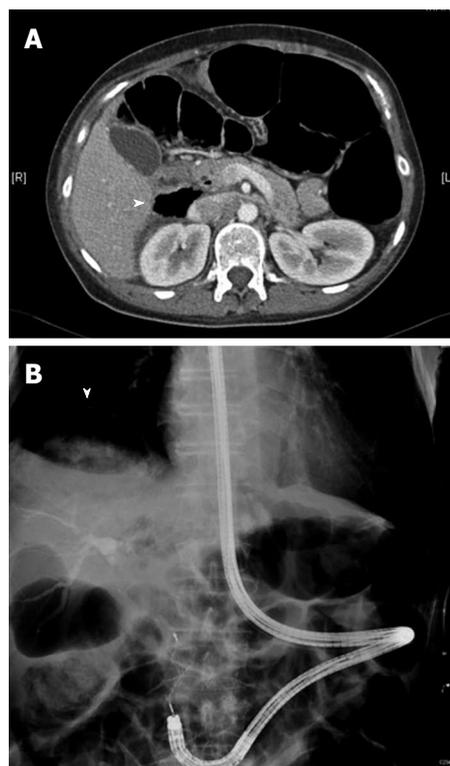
A patient with Roux-en-Y gastric bypass. A: Computed tomography of a retroperitoneal perforation (white arrow) at the level of papilla of Vater after sphincterotomy and sphincteroplasty in a patient with Roux-en-Y gastric bypass; B: Radiological view of hepatic capsule dehiscence without free abdominal air (white arrow) due to barotrauma in the closed afferent limb during single-balloon enteroscopy endoscopic retrograde cholangiopancreatography in a patient with Billroth II partial gastrectomy. Common bile duct stone retrieval with a basket is being performed.
